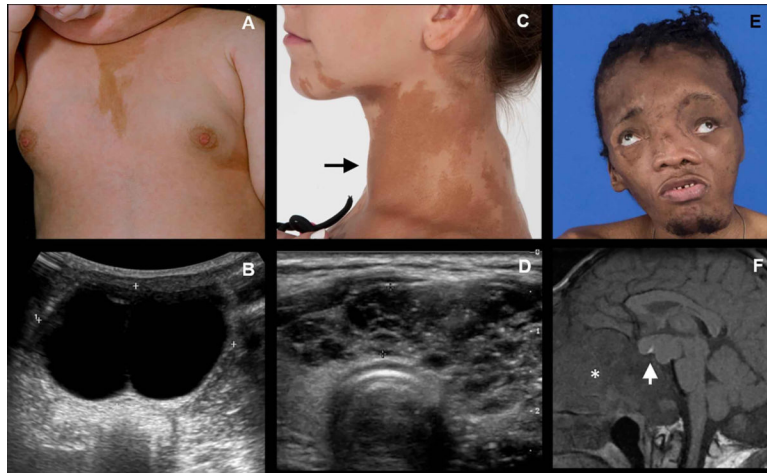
Clinical and radiographic features of McCune-Albright Syndrome (MAS). (A) An infant with a typical appearing café-au-lait macule and breast budding; (B) corresponding pelvic ultrasound shows a large estrogen-producing ovarian cyst. (C) Adolescent with typical appearing café-au-lait macules affecting her neck and jaw, and a goiter (arrow) consistent with hyperthyroidism; (D) corresponding thyroid ultrasound demonstrating an abnormal, heterogenous cystic gland. (E) Patient with uncontrolled growth hormone excess resulting in macrocephaly and vision loss; (F) T1-weighted MRI with large growth hormone-secreting pituitary adenoma (arrow) and thickened cranial base secondary to fibrous dysplasia.
